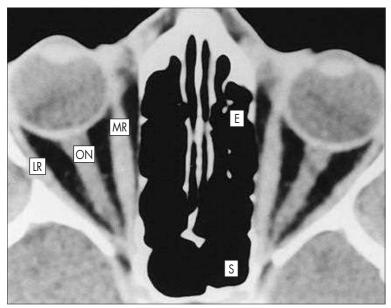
Axial CT Scan Through the Midorbit. The globe and optic nerve are seen in the axial plane, along with the medial and lateral rectus muscles. *E,* Ethmoid sinus; *LR,* lateral rectus; *MR,* medial rectus; *ON,* optic nerve; *S,* sphenoid sinus.
